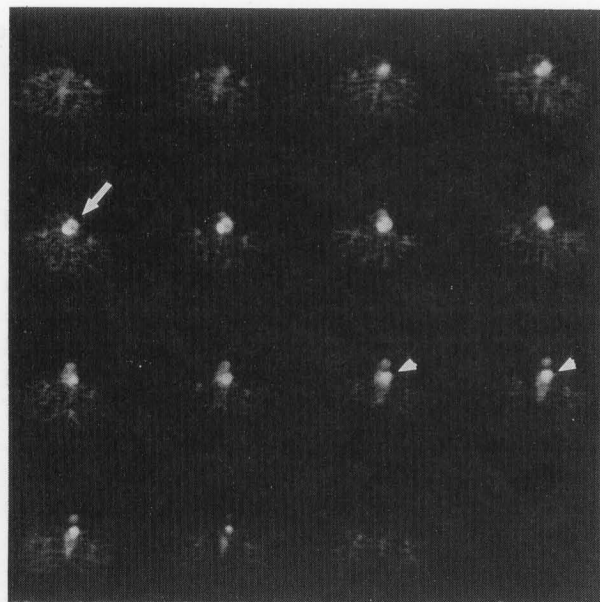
FDG-PET transaxial sections sequentially from the lower pelvis to the inguinal region. An intense, focal uptake of FDG is noted in the caudal left hemiscrotal region (arrowhead), as well as an intense, ring-like uptake of FDG in the cranial scrotal region (arrow). The two lesions are contiguous to each other. There is also urethral activity (urinary FDG) in front of the symphysis pubis.
